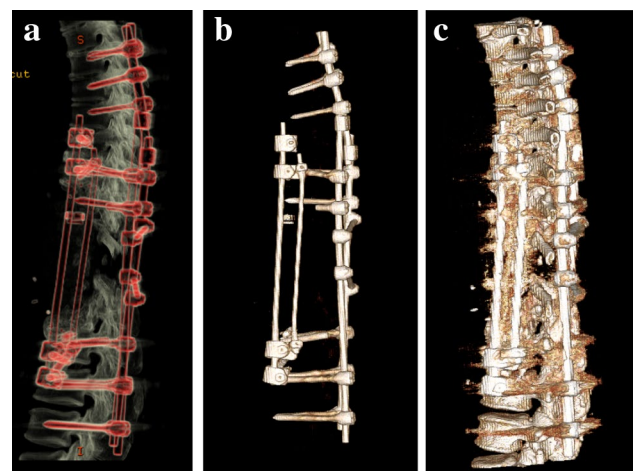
F/u 05/2016 3D CT scan of the spine. A situation 1 year after anterior–posterior revision surgery in 2015. a Overview of the situs during the anterior; b only the implants are reformatted, and c implants are well integrated. No hint for implant failure. No fracture
